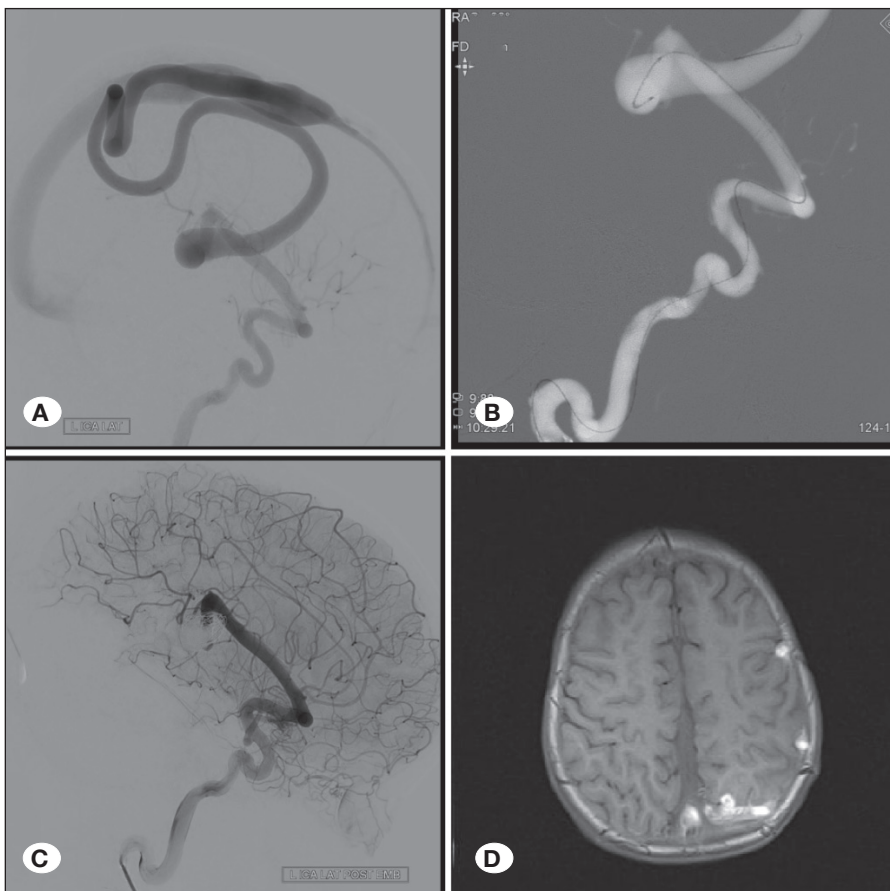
A 1-year-old male patient presented with macrocrania and hydrocephalus. A) Left internal carotid angiography lateral projection. There is a single-hole high-flow fistula fed by the M2 branch of left middle cerebral artery which drains to a superficial serpiginous dilated vein, then superior sagittal sinus. B) Although the proximal venous part of the fistula site has relatively dilated, deploying coils without migration would be difficult. This anatomy is ideal for using the double-microcatheter technique. C) Control angiography shows total occlusion with coils only. D) MR imaging 15 days later demonstrates subacute thrombosis in the fistula's serpiginous vein which also extends up to the superior sagittal sinus.
